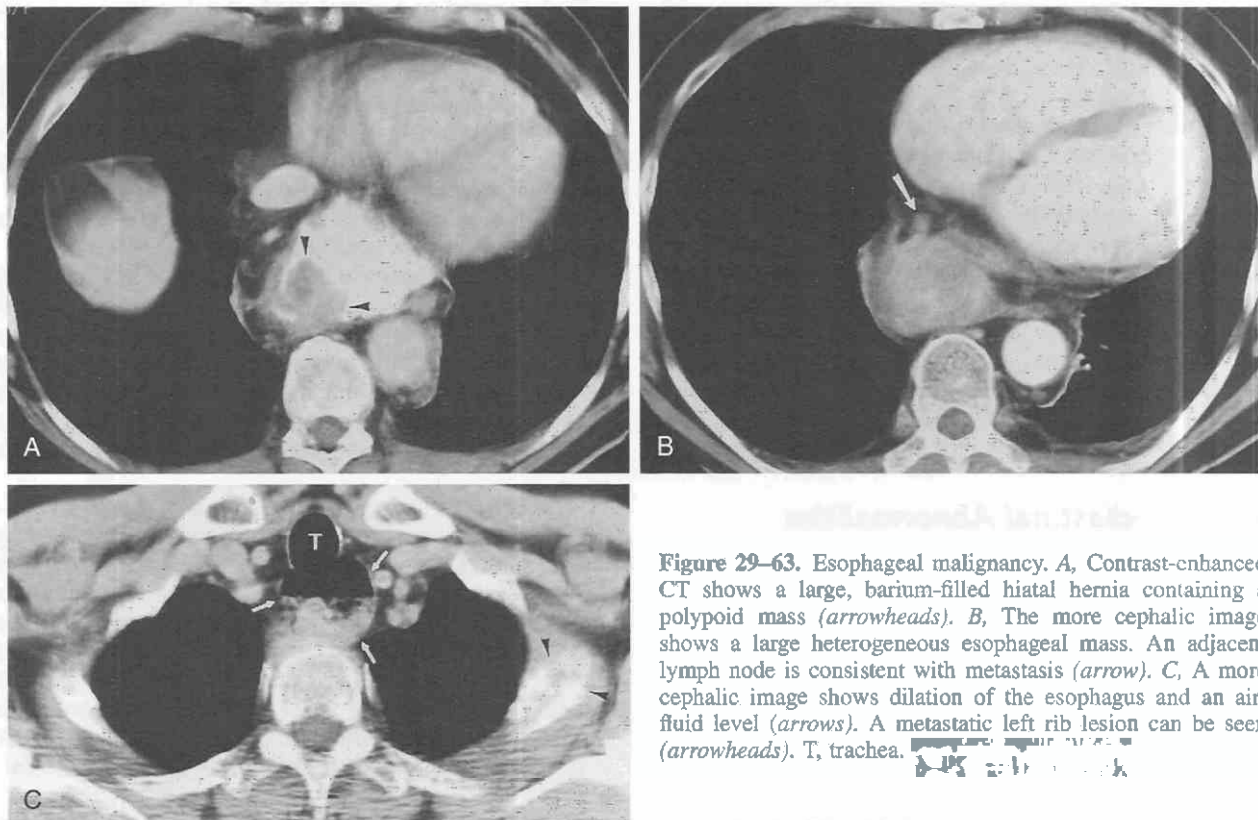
Esophageal malignancy. A, Contrast-enhanced CT shows a large, barium-filled hiatal hernia containing a polypoid mass (arrowheads). B, The more cephalic image shows a large heterogeneous esophageal mass. An adjacent lymph node is consistent with metastasis (arrow). C, A more cephalic image shows dilation of the esophagus and an air-fluid level (arrows). A metastatic left rib lesion can be seen (arrowheads). T, trachea.
